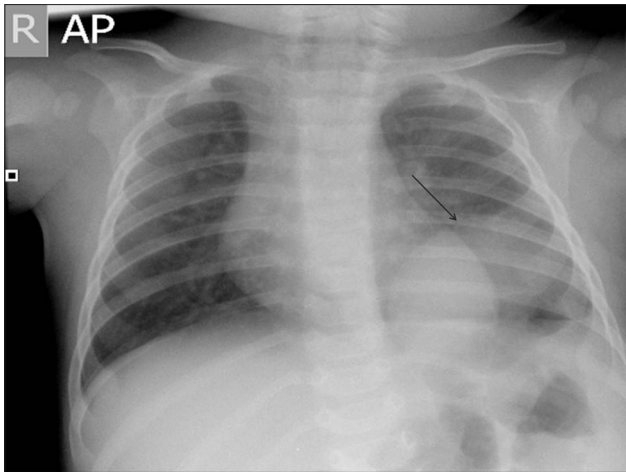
Chest radiograph demonstrating an ovoid mass in the left hemithorax, abutting the left hemidiaphragm
